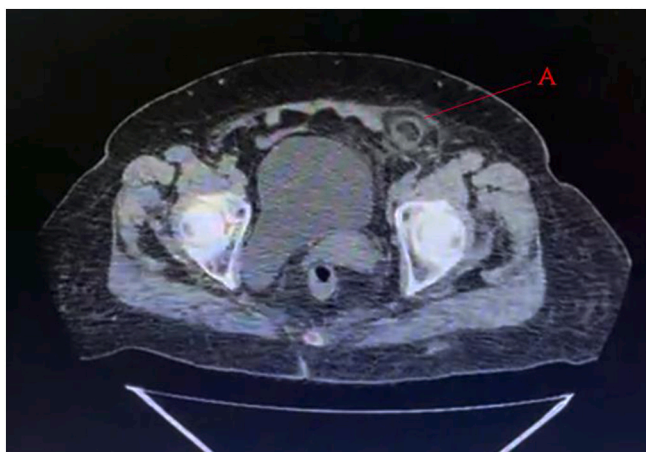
Abdominal computed tomography findings. An oval structure found in left lower quadrant measuring approximately 2.0 cm (A).
